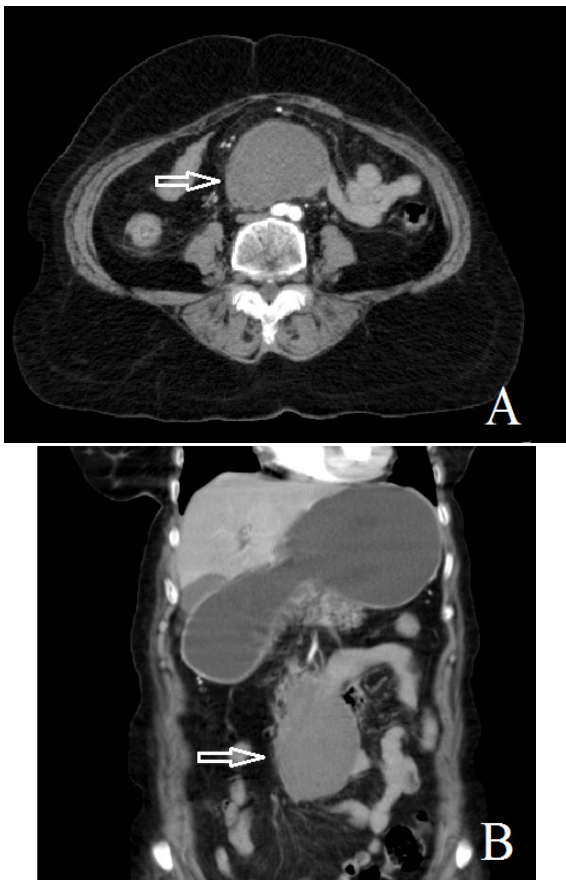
CT scans showing well defined, round tumoral lesion located at the fourth part of the duodenum.
